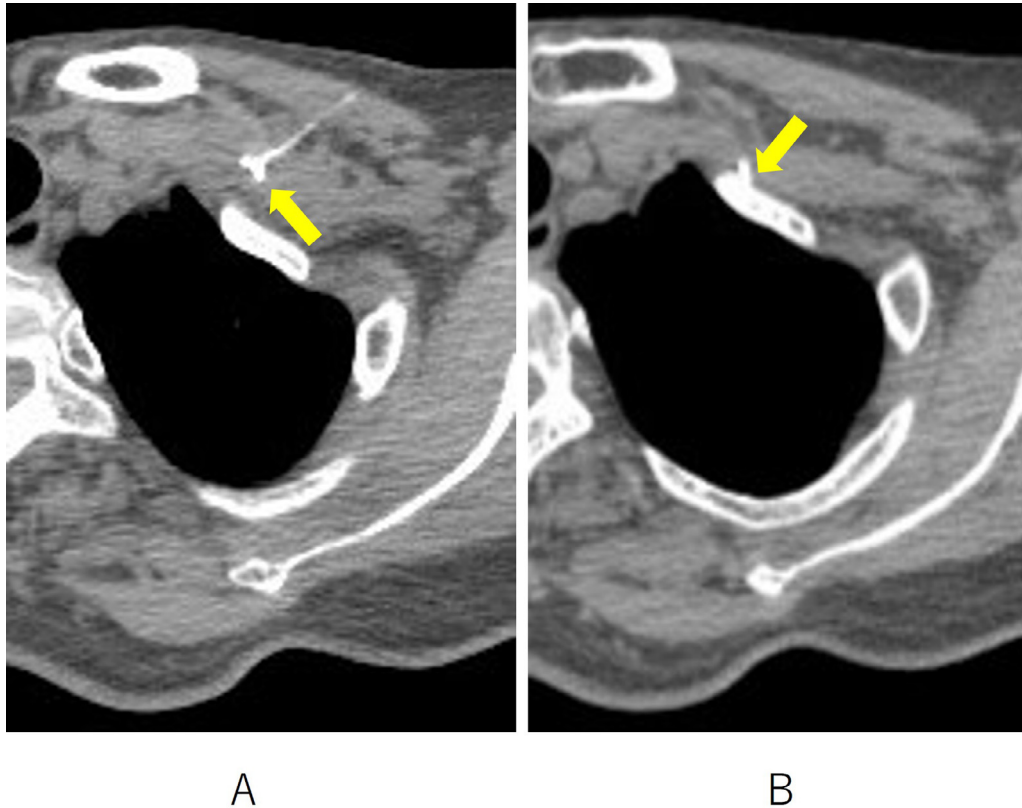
A. The CT image also revealed a knot like shadow near the tip of the guidewire (yellow arrow).
